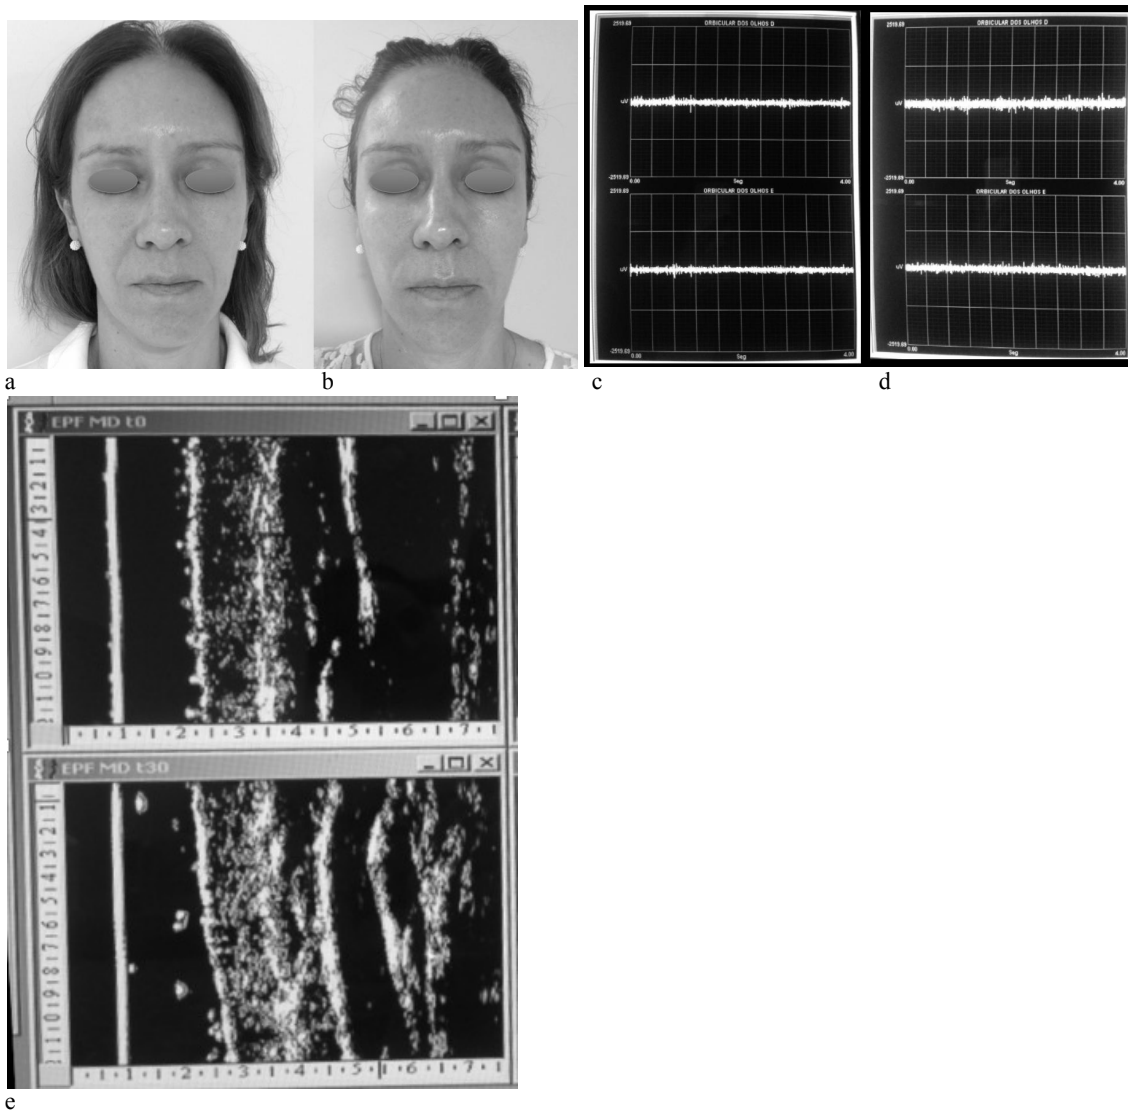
Digital photographs of face at the initial time (a) and after 8 sessions of photobiomodulation in association with Orofacial Exercises (b); EMG of orbicular oculi (c – above – right side, and, c – below – left side); and echogenicity (skin ultrasonography) of right masseter before (e – above) and after treatment (c – below).
